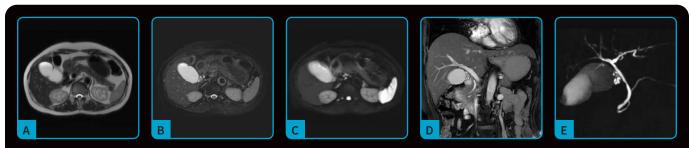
Case 1, IPMN. All sequences acquired on the upgraded SIGNA Artist Evo with AIR Recon DL. (A) Axial T2w, 0.9 x 1.1 x 5 mm, 23 sec.; (B) axial T2w FatSat, 1.1 x 1.9 x 5 mm, 45 sec.; (C) axial DWI, 2.8 x 1.9 x 6 mm, 3:48 min.; (D) coronal FIESTA FatSat, 2 x 1.4 x 4 mm, 21 sec.; and (E) 3D MRCP with breath-hold, 1.3 x 1.4 x 1.4 mm, 20 sec.
